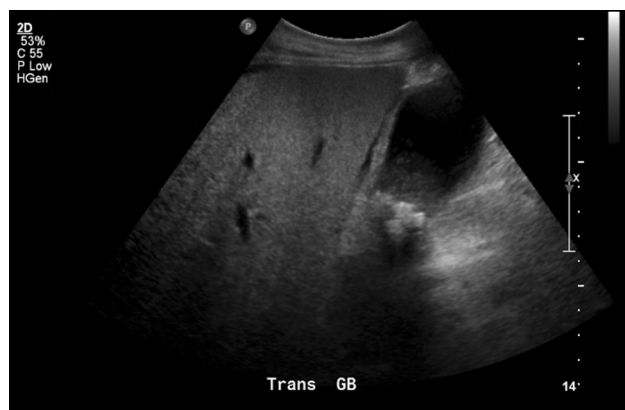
Abdominal ultrasound showing distended gallbladder and pericholecystic fluid was suggestive of acute cholecystitis
